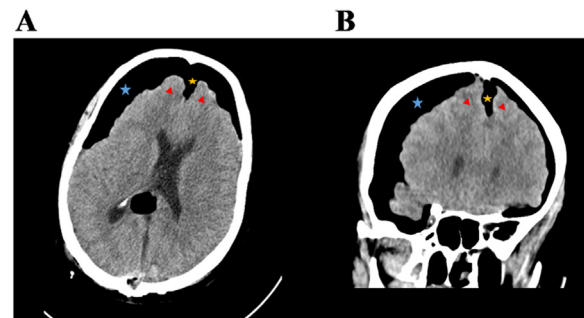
Computed tomographic imaging of the brain in the axial and coronal sections (Panel A and B respectively) demonstrates presence of air (blue star) inside the cranial vault (pneumocephalus) after resection of a pineal meningioma. Possibility of tension pneumocephalus is suggested by the presence of the Mount Fuji radiographic sign in Panel A; the frontal lobes (red triangles) are compressed by the subdural air collection (blue star) with widening of the interhemispheric fissure (gold star), creating a resemblance to the silhouette of Mount Fuji.
